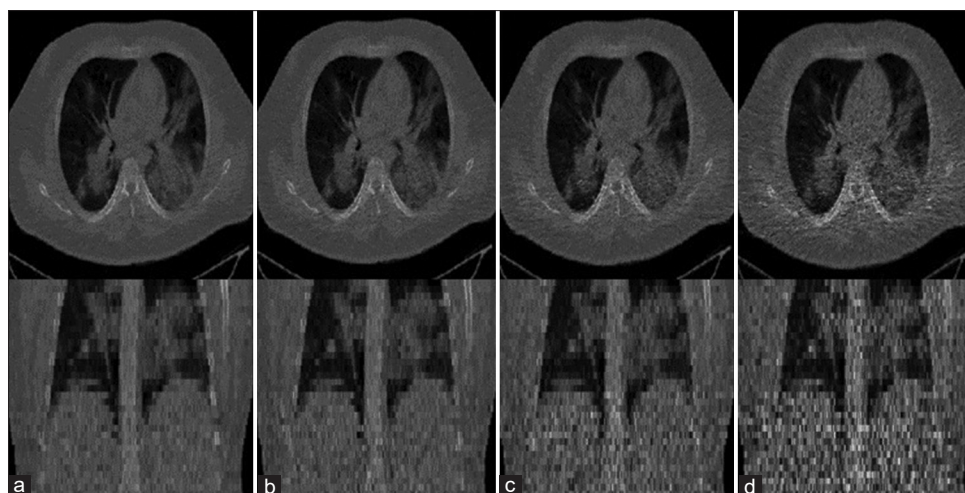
(a) 60% low-dose, (b) 40% low-dose, (c) 20% low-dose, and (d) 10% low-dose CT images after application of the bilateral filter. CT – Computed tomography
